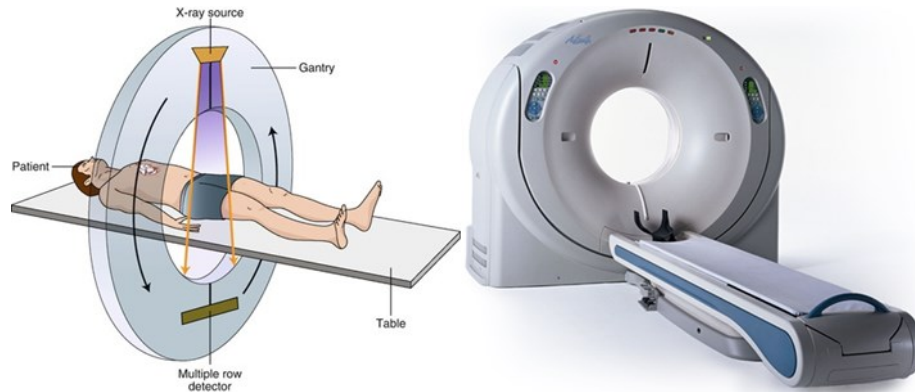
7 Representation and real appearance of the CT gantry structure.
